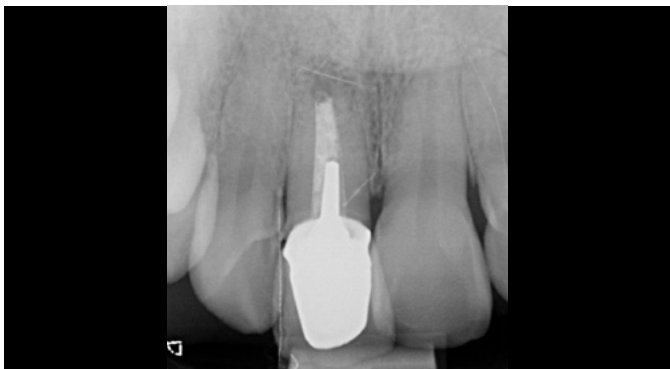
Preoperative periapical radiograph showing apical lesion at tooth 11
